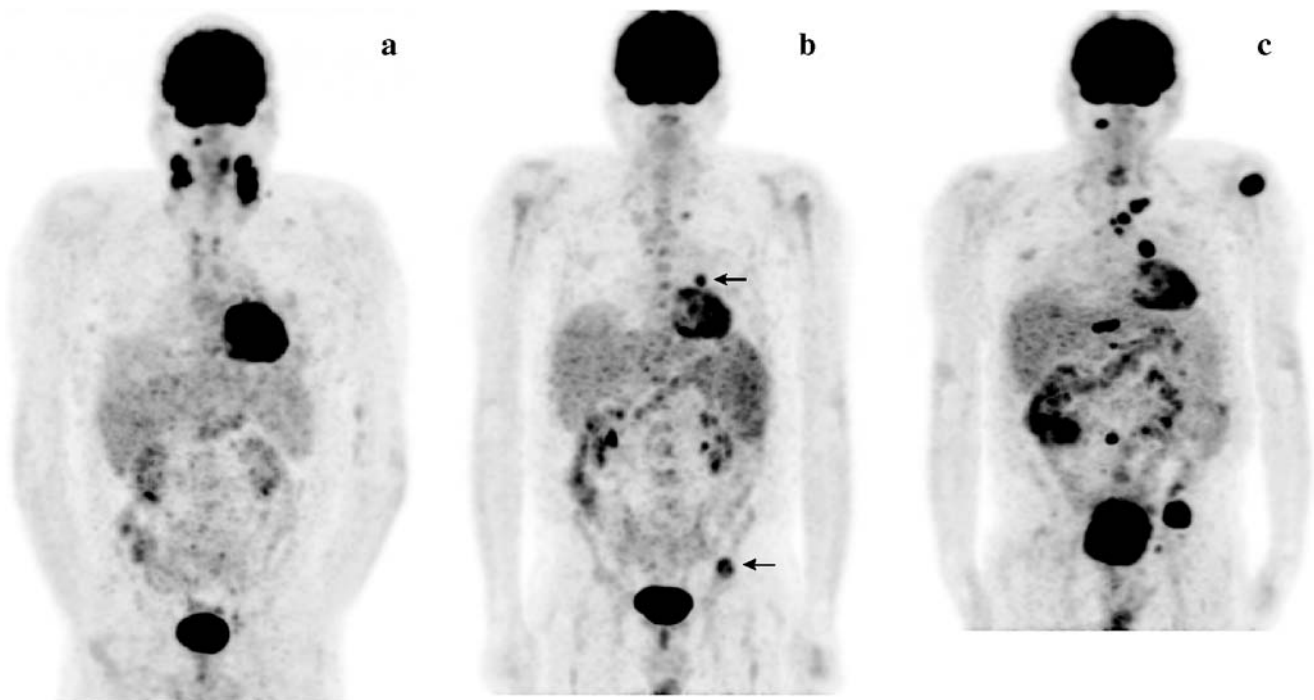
Maximum intensity projection of the coronal FDG–PET images of a patient suspected of recurrence 6 years after the initial diagnosis of a peripheral T-cell NHL (case 3) at recurrence (a), before and 2 months after BEAM chemotherapy with peripheral blood stem cell transplantation (b and c, respectively). At recurrence, a stage IV is confirmed
